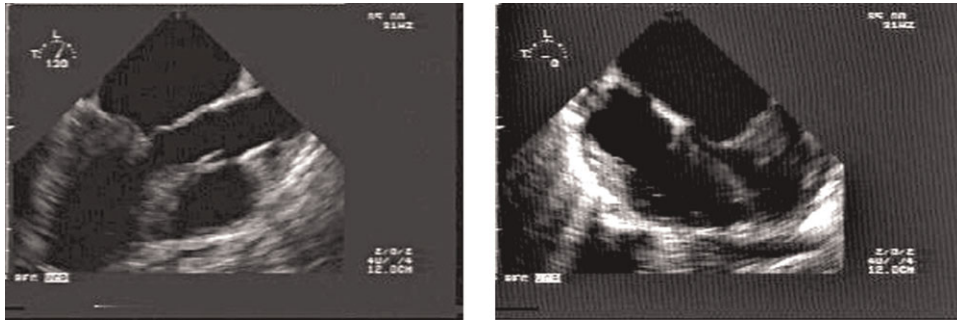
Horizontal (right panel) and 120° (left panel) transoesophageal echocardiogram views showing a very homogeneous echogenic mass coming from both leaflets of the mitral valve and occupying much of the left ventricular inflow tract.
